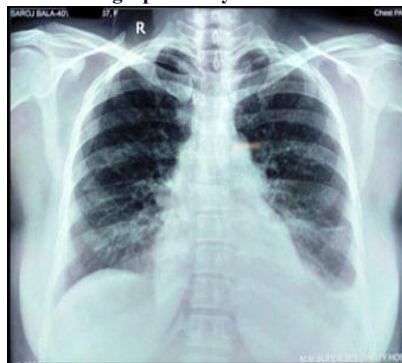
Chest Radiograph on Day 5.
